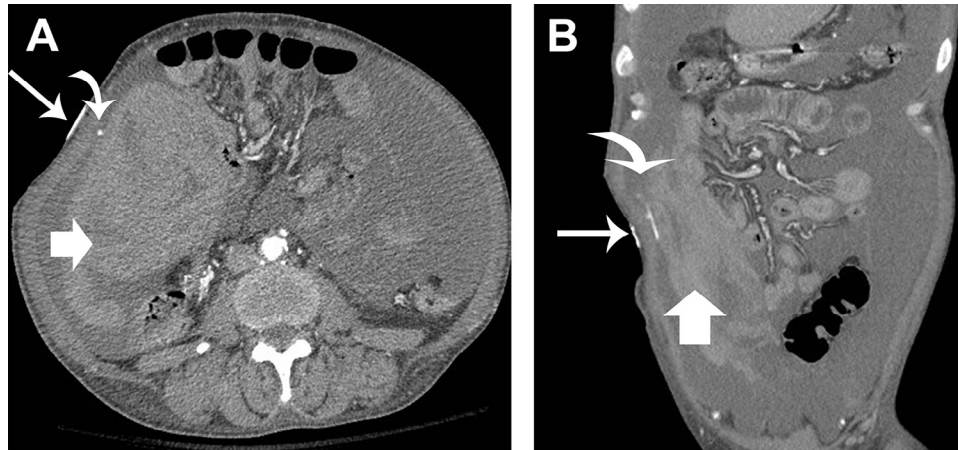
Axial (A) and coronal (B) images from a contrast-enhanced computed tomography scan showing bandage over the site of paracentesis (long arrow), extravasation of contrast indicating active bleeding (curved arrow), and a large intraperitoneal blood clot (short arrow).
